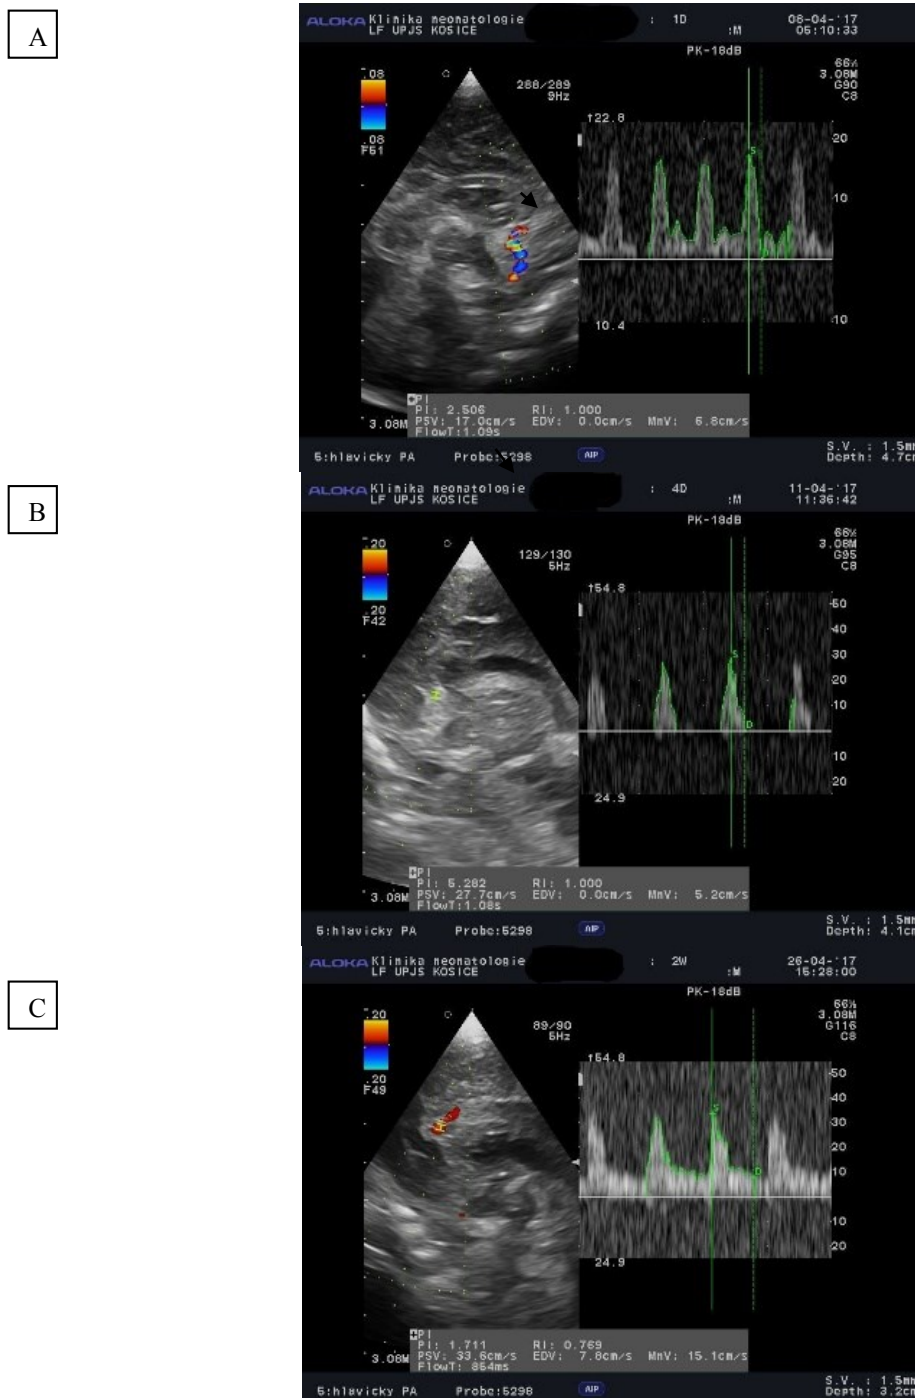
Changes of the doppler flow curves in the brain.
